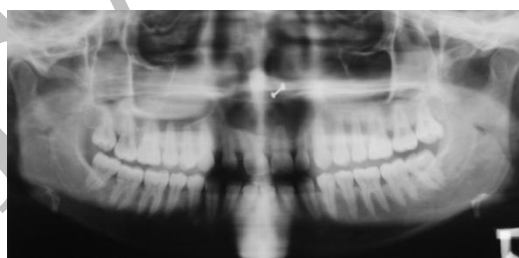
Panoramic radiograph showing well defined radiolucency in mid palatal region
